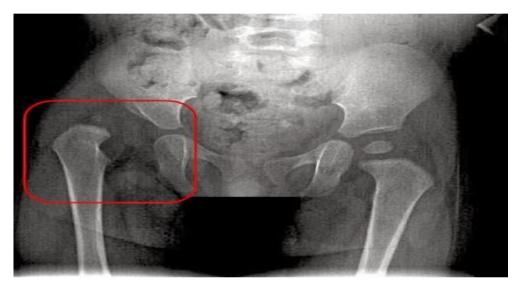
Plain film x-ray of right sided DDH Adapted from https://hipdysplasia.org/
